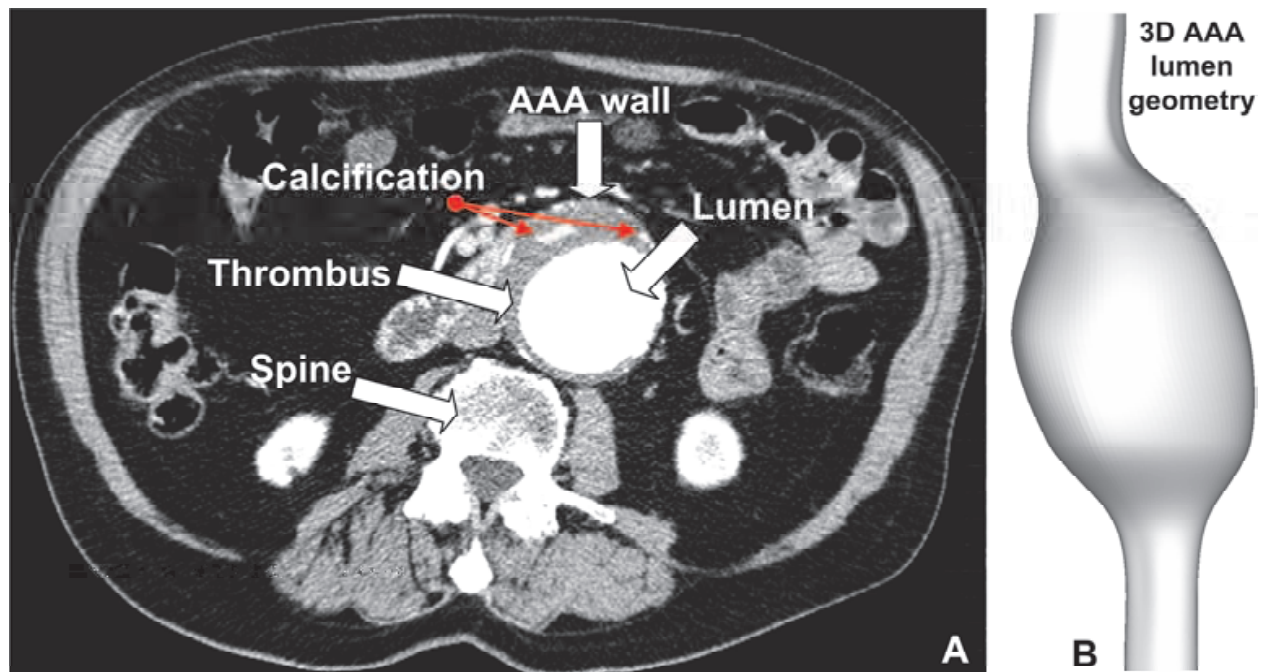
CT scan and 3D reconstruction of the investigated section of the abdominal aorta. Axial cross-section CT slices are used for the three-dimensional reconstructions (A). 3D reconstruction of examined AAA (B). Anterior-posterior asymmetric AAA model result from the CT-scan.
